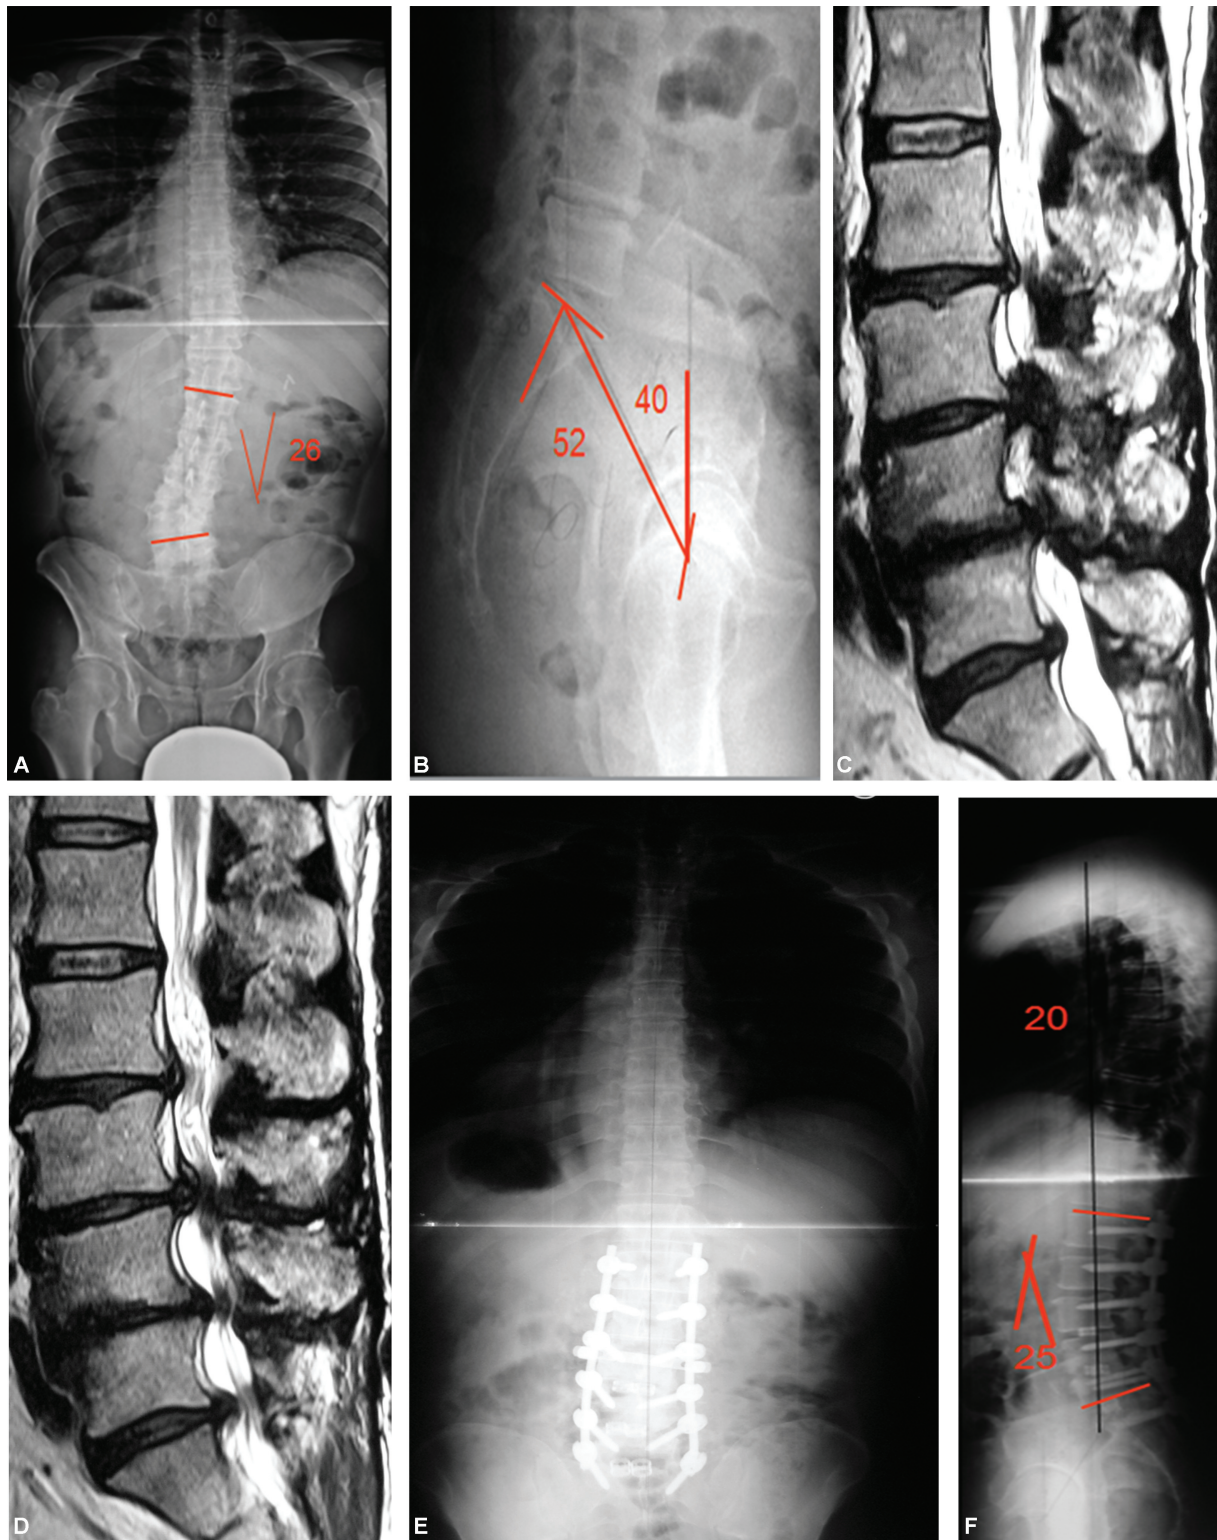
Degenerative scoliosis: (A and B) Radiography: degenerative scoliosis with decreased lumbar lordosis and increased pelvic version. (C and D) Sagittal magnetic resonance imaging: L2 to S1 spinal stenosis. (E and F) Postoperative radiography: deformities correction with increased lumbar lordosis and decreased pelvic version.
